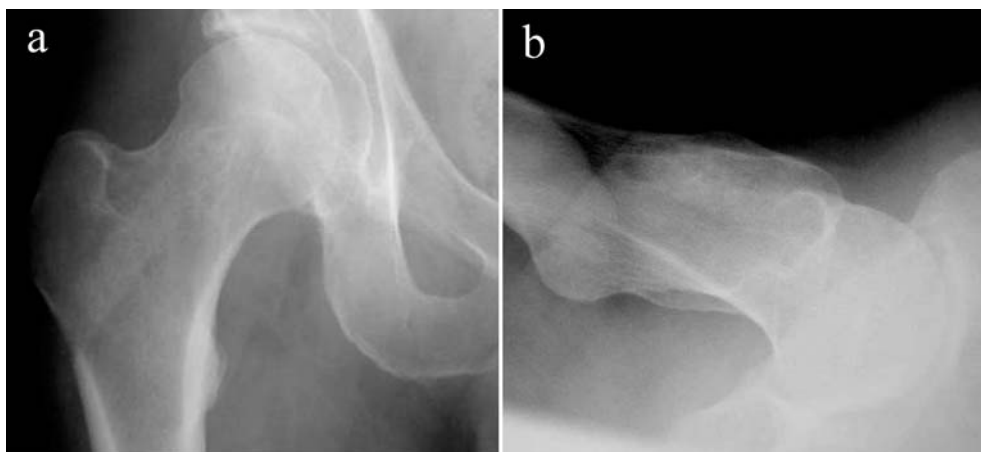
Follow up radiographs (Case 1). AP and (b) lateral radiographs taken at 6 month follow up. Radiographically the lesion has been replaced by bone at a higher density than the surrounding cancellous bone.
